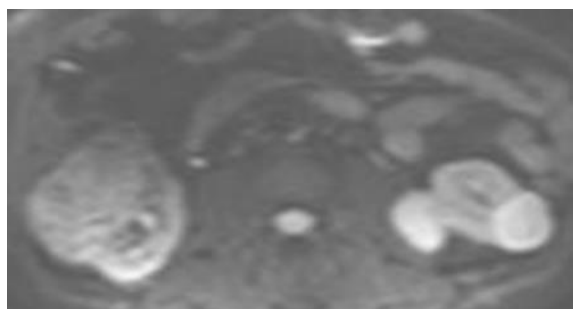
axial image of Diffusion WI MRI sequence ,renal mass shows restricted diffusion.
